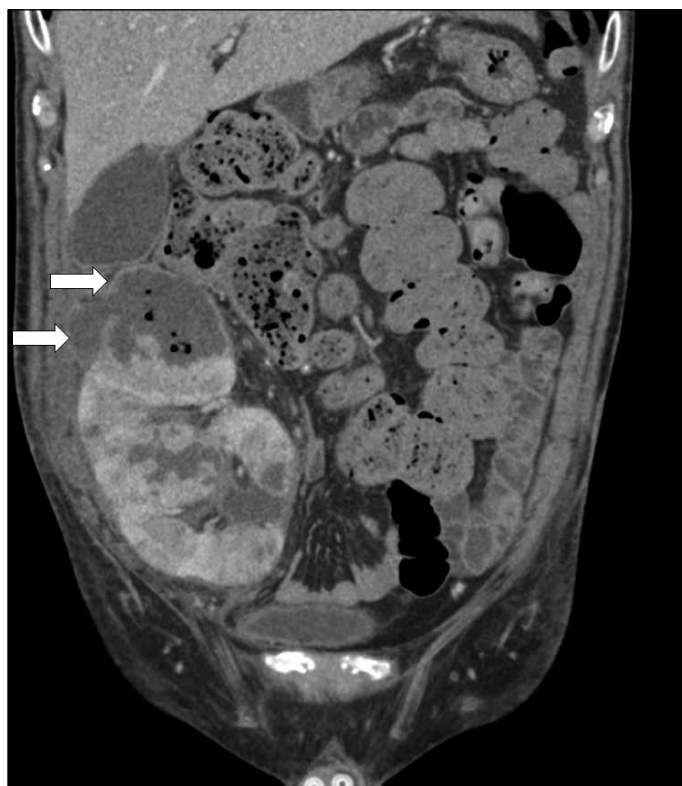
A computed tomography scan shows the kidney allograft in the right iliac fossa with two abscesses on upper pole and gas in parenchyma.
